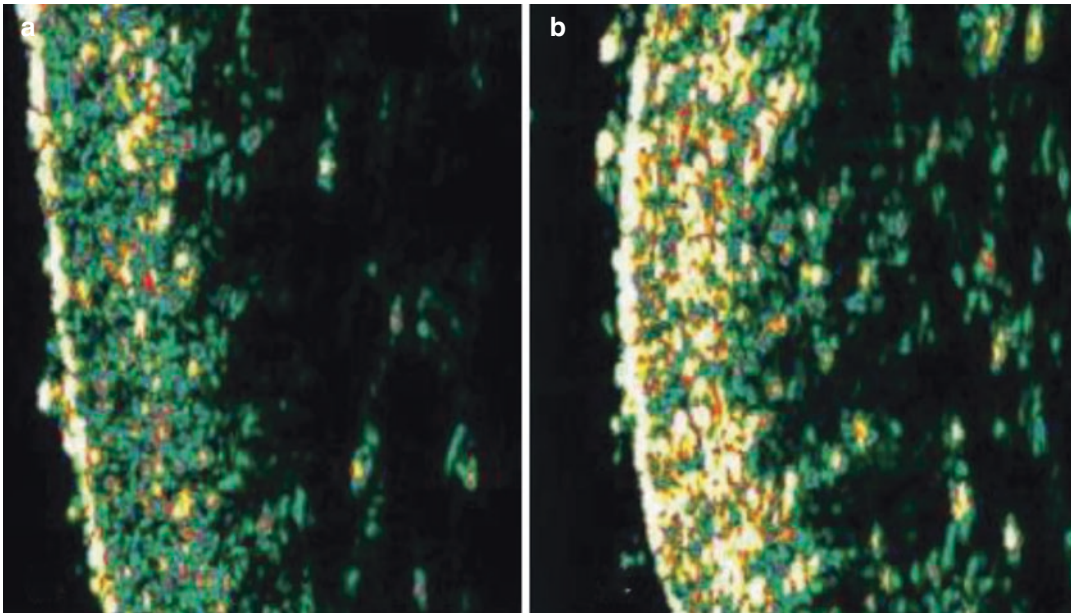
Skin morphology effect was evaluated by ultrasonography parameters, using a 20-MHz probe to measure thickness and density of the subepidermal low echogenic band (SLEB). In (a), the skin morphology before PRP
